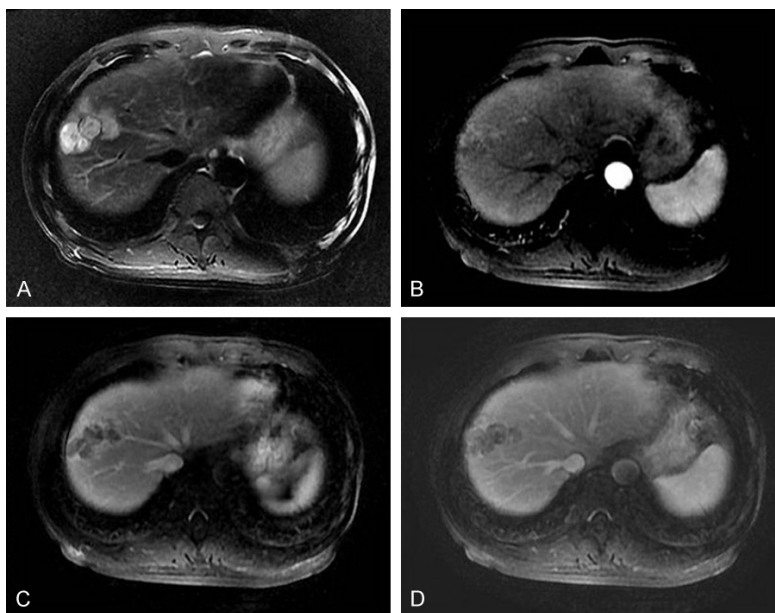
A confluent hepatocellular carcinoma of the multinodular type in a 56-year old man confirmed as MVI-positive by pathologic analysis. A T2-weighted image (A) shows a hyperintense tumor formed by a cluster of contiguous nodules. T1-weighted images at arterial phase (B), portal-venous phase (C), and equilibrium phase (D) show arterial phase enhancing and washout on portal-venous phase and equilibrium phase. Abbreviation: MVI, microvascular invasion.
